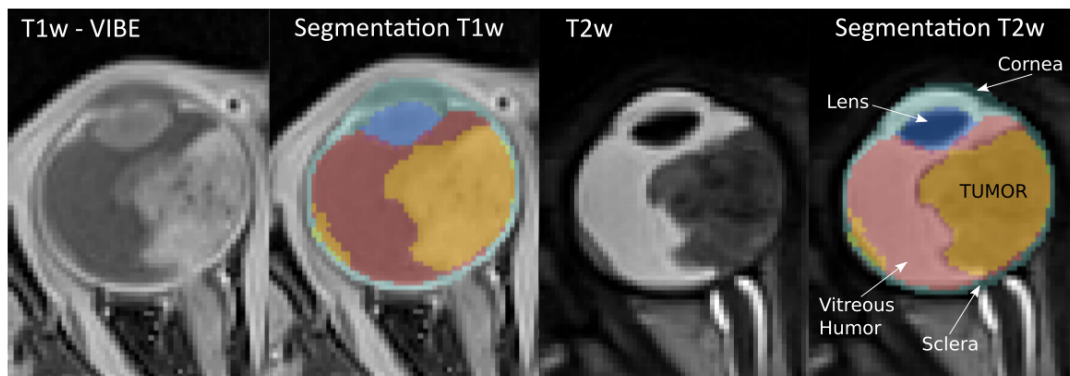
Segmentation of medical images in MRI : Example of segmentation of medical images in 3D eye MRI. Manual delineation of the sclera, the cornea, the vitreous humor and the lens of a retinoblastoma patient. The process of manual delineation of these images may take between 2-3 hours.
